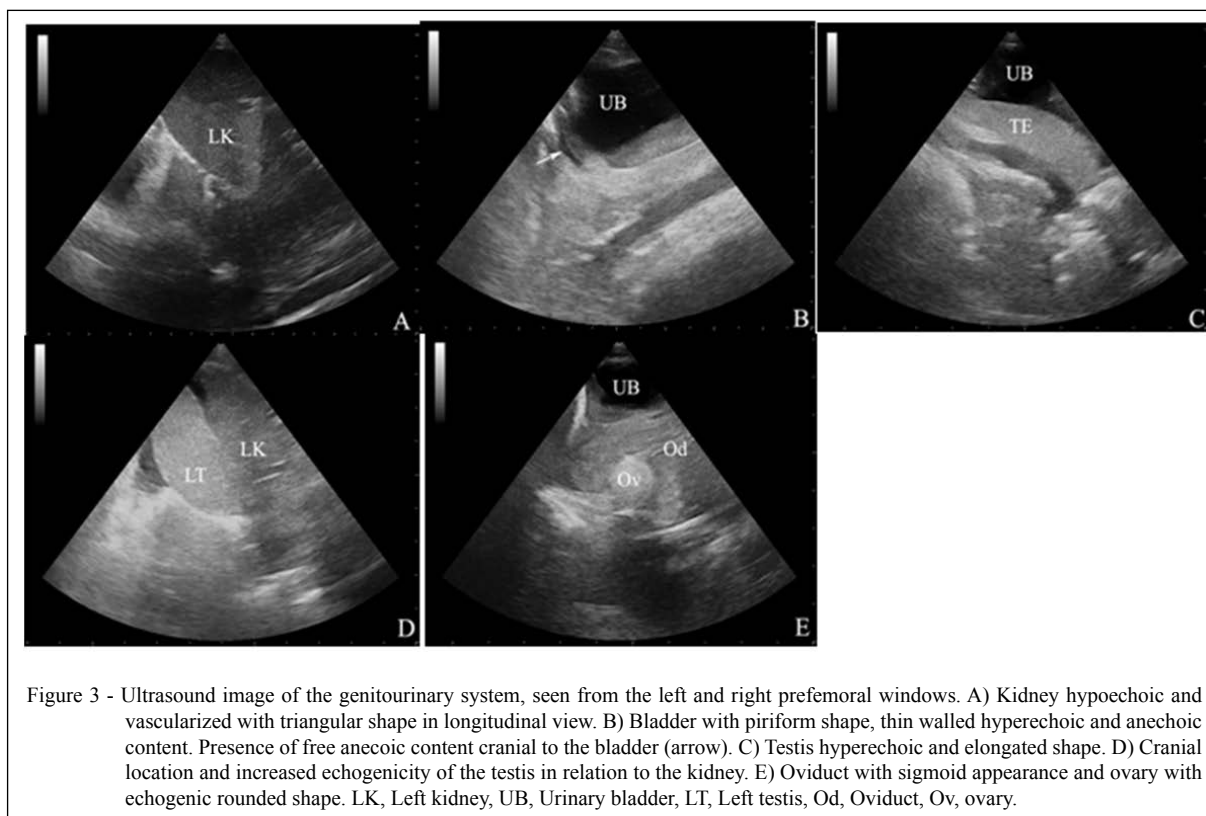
Ultrasound image of the genitourinary system, seen from the left and right prefemoral windows. A) Kidney hypoechoic and vascularized with triangular shape in longitudinal view. B) Bladder with piriform shape, thin walled hyperechoic and anechoic content. Presence of free anechoic content cranial to the bladder (arrow). C) Testis hyperechoic and elongated shape. D) Cranial location and increased echogenicity of the testis in relation to the kidney. E) Oviduct with sigmoid appearance and ovary with echogenic rounded shape. LK, Left kidney, UB, Urinary bladder, LT, Left testis, Od, Oviduct, Ov, ovary.
